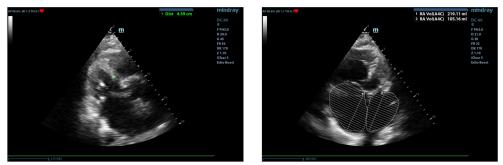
c.1. Dilation of both left (105 ml) and right atrium (219 ml), nondilated left ventricle in a case with restrictive cardiomyopathy (left 2D, parasternal long axis view; right 2D, apical 4-chambers view)
